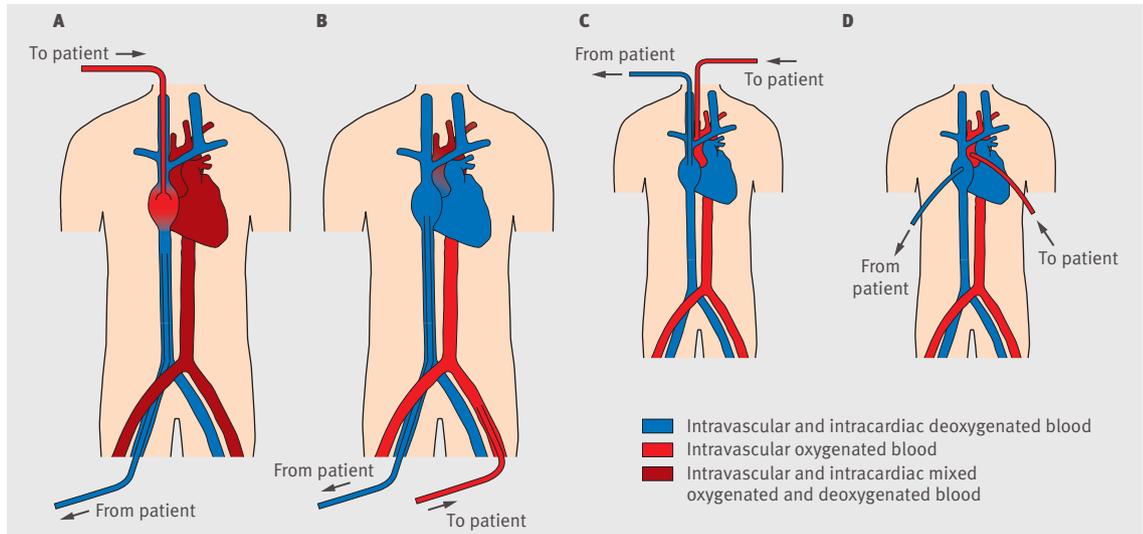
A: an alternative venous-venous extracorporeal life support (ECLS) cannulation; deoxygenated blood is drained from the femoral vein with oxygenated blood being returned to the right atrium. B-D: various venous-arterial configurations. B: blood is drained from the femoral vein and returned to the femoral artery where oxygenated blood flows in a retrograde direction up along the aorta; when some residual cardiac function remains, oxygenated ECLS blood mixes with deoxygenated blood ejected from the left ventricle. C: a cannulated carotid artery, a site often used in infants. D: transthoracic right atrial and aortic cardiopulmonary bypass cannulas. Blue: intravascular and intracardiac deoxygenated blood; red: intravascular oxygenated blood; dark red: intravascular and intracardiac mixed oxygenated and deoxygenated blood
